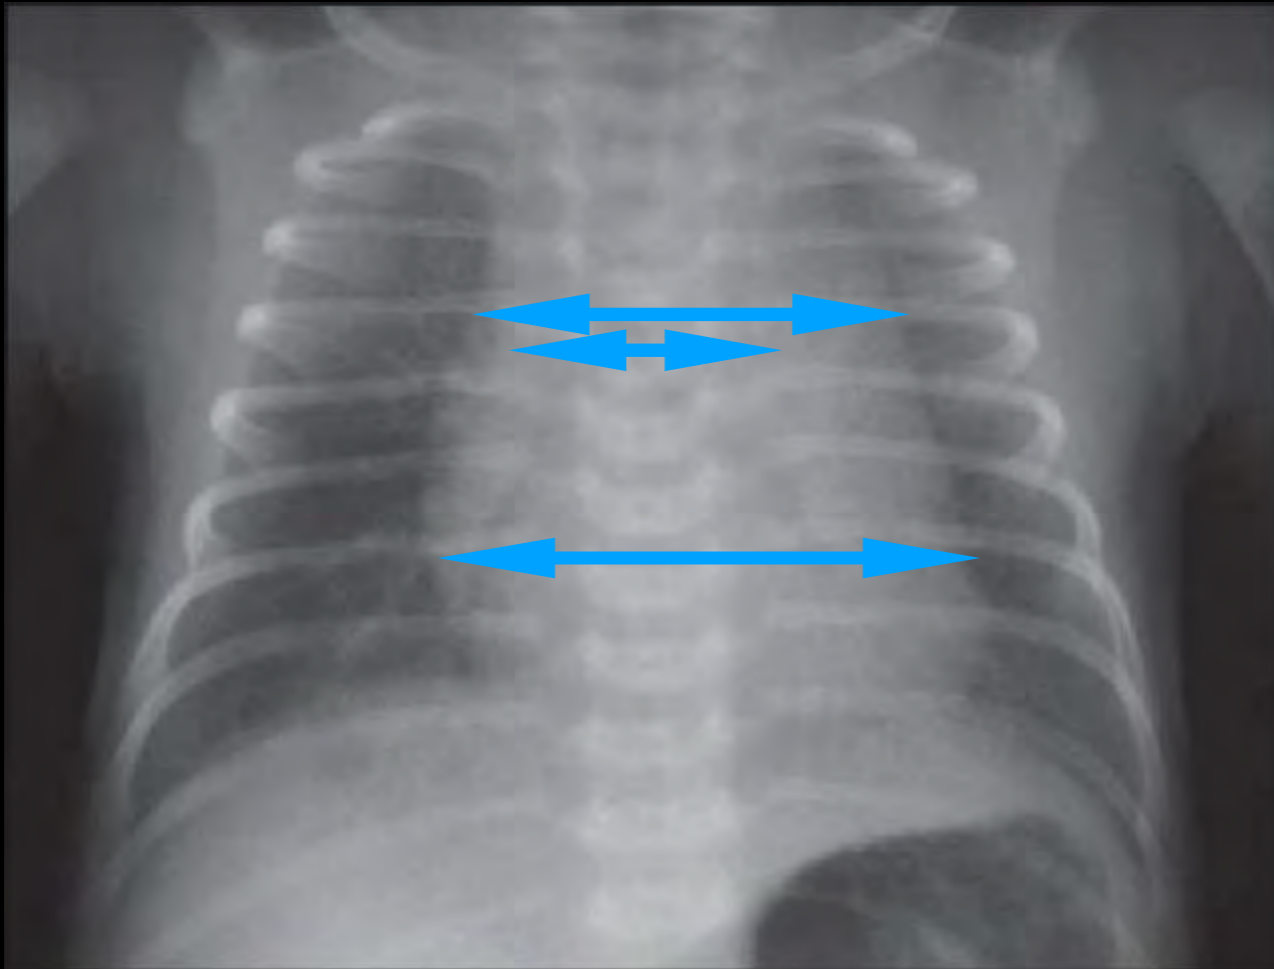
Normal chest x-ray of a two-hour-old newborn infant, in compliance
